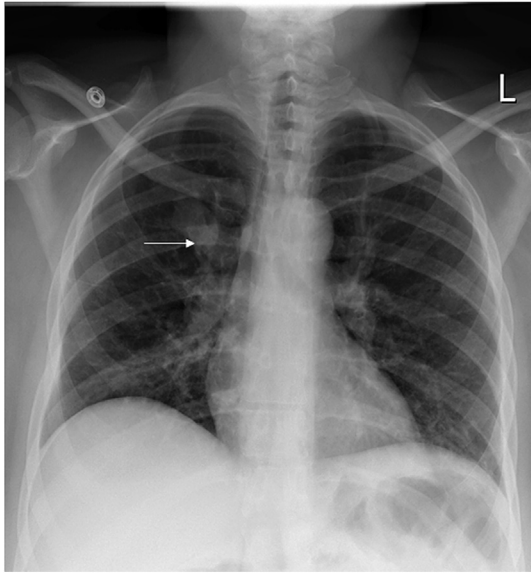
Chest radiography showed a lobulated medial right upper lobe nodule (arrow).
